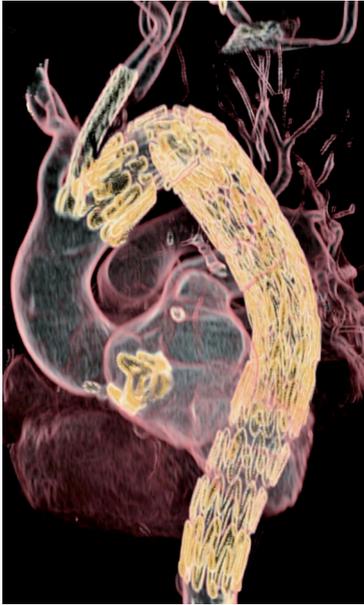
Computed tomography angiography shows a patent stent graft after successful thoracic endovascular aortic repair of a ruptured descending thoracic aortic aneurysm with placement of a chimney stent in the left common carotid artery.
